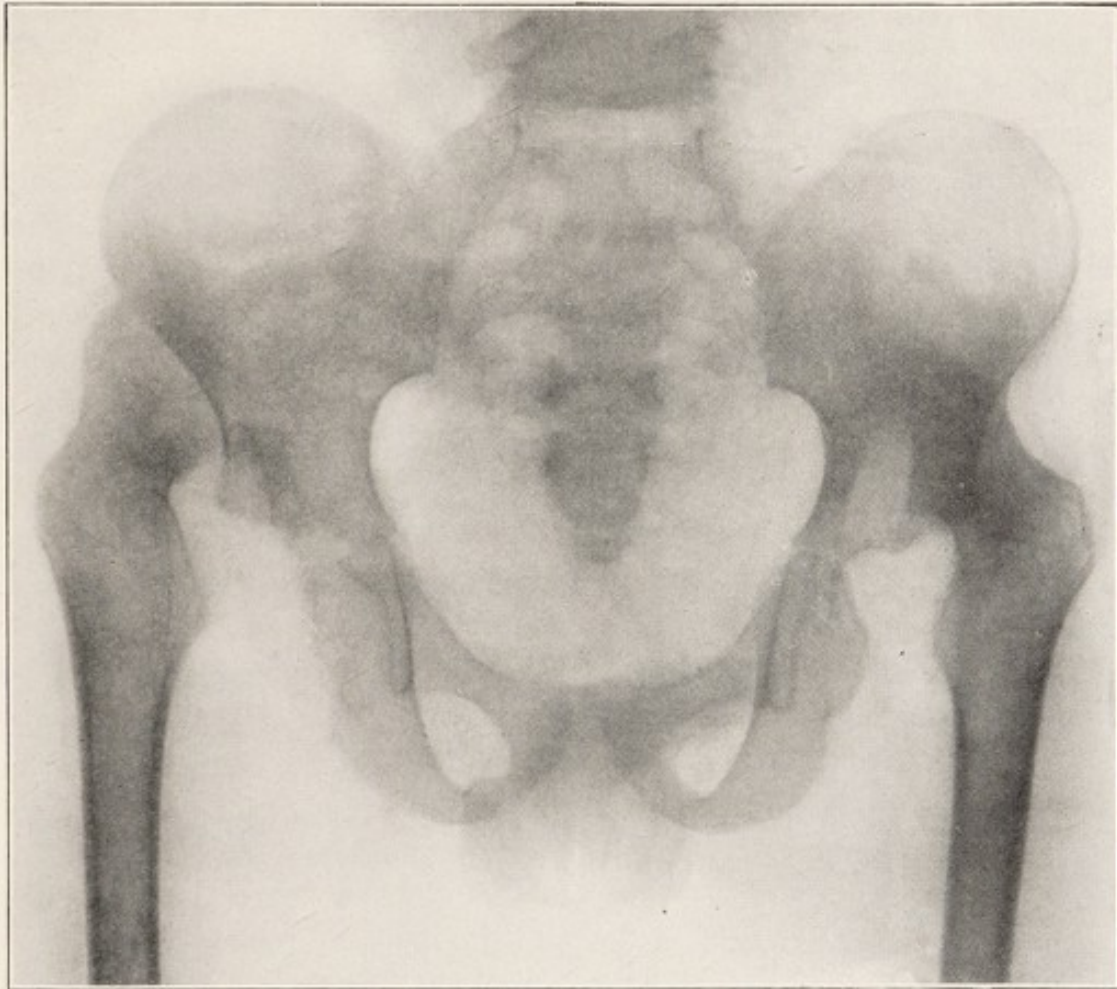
X-RAY SHOWING BILATERAL DISLOCATION OF HIPs RESULTING FROM ACUTE INFECTIOUS ARTHRITIS.
